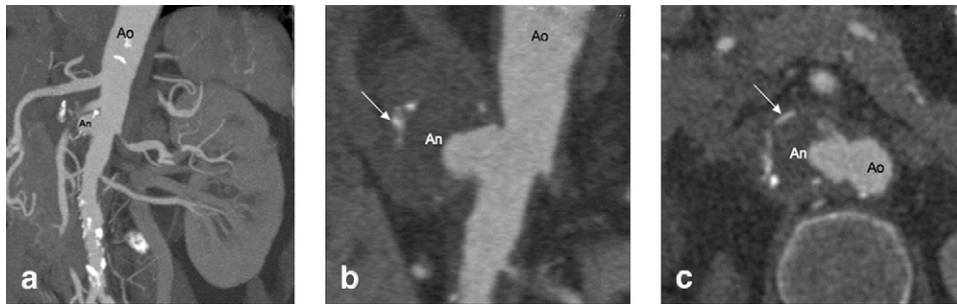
Computed tomography angiography shows the saccular aneurysm (*An*) of the abdominal aorta (*Ao*). The aneurysmal wall is calcified (*white arrow*).
